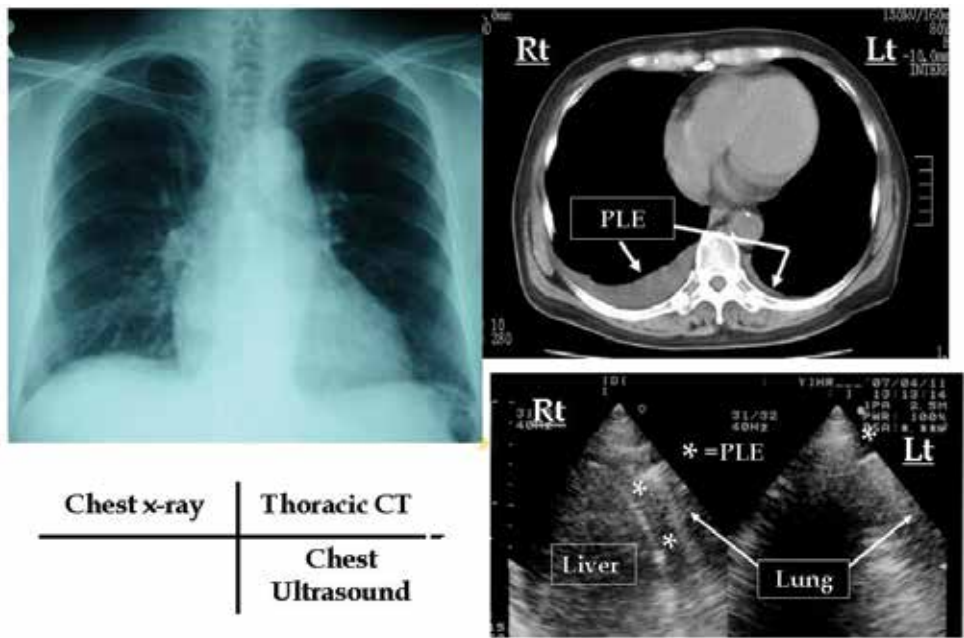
Chest x-ray film, x-ray computed tomogram, and chest ultrasound obtained from a 78-year-old male with worsening heart failure due to hypertensive heart disease. Lt = left; PLE = pleural effusion; Rt = right
